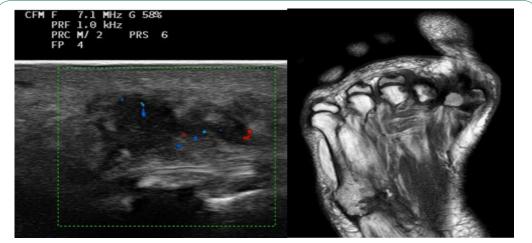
Ultrasound of the feet (a) showing non-homogeneous hypoechoic non-compressible masse close to the bone surface, with a central anechoic area and diffuse peripheric Color Doppler signal. MRI of the feet (b) showing a non-homogeneous lesion of approximately 23x20 mm, adjacent to the fifth metatarsal bone, with high signal on T2 images.
